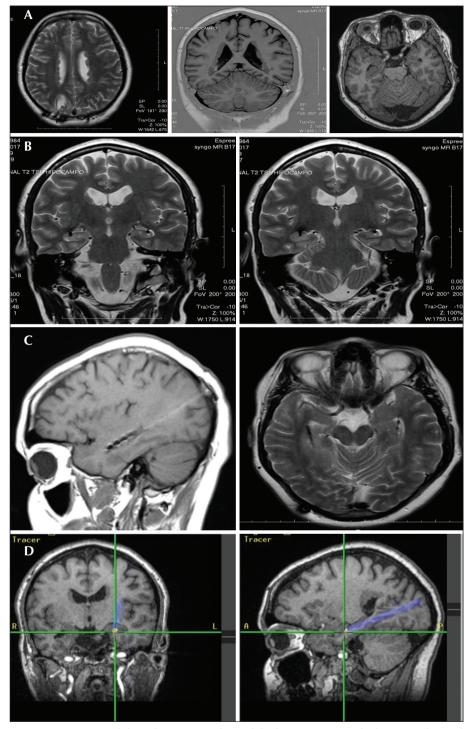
MRI investigation. (A) Extensive bilateral periventricular nodular heterotopia. (B) The location of DBS electrodes bilaterally; contacts are located in the lateral hippocampus proper (left hippocampus) or in the heterotopia/hippocampus interface (right mesial region). (C) Axial and sagittal MRI slices showing the position of the contacts postoperatively. (D) Intraoperative neuronavigational snapshot during electrode insertion.
